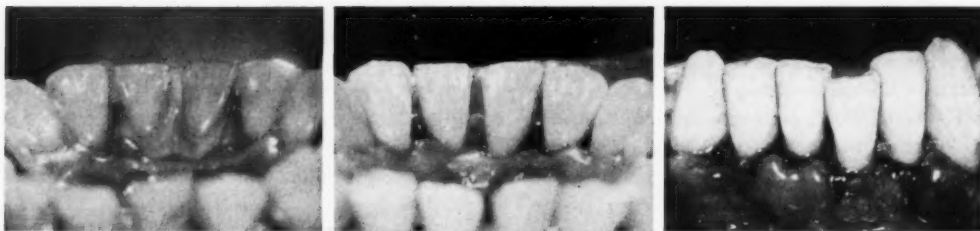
Left: Lingual view of the lower anterior teeth before ultrasonic scaling. Center: View of the same teeth after ultrasonic scaling. Right: The right cuspid, lateral and central incisors were scaled ultrasonically; the left cuspid, lateral and central incisors were scaled by hand
